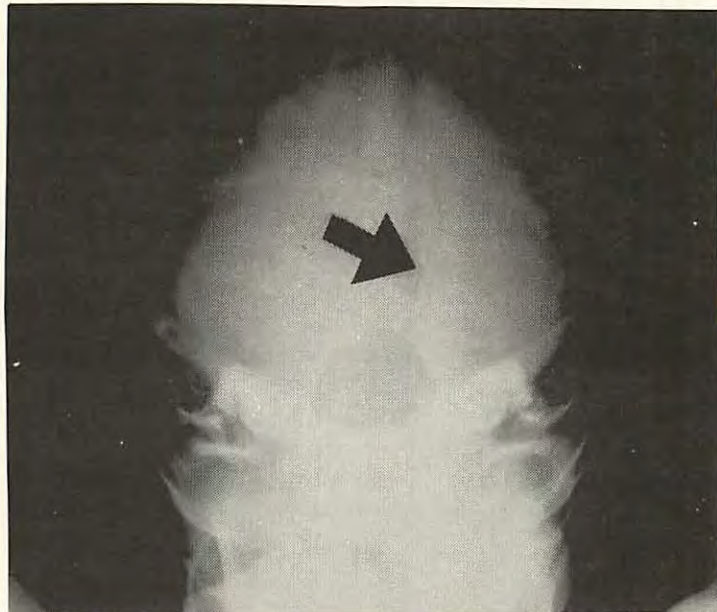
This radiograph is of a 27 month old male. The arrow indicates a long linear fracture of the occiput running from the superior portion into the foramen magnum. There is no evidence of depressed fracture.
